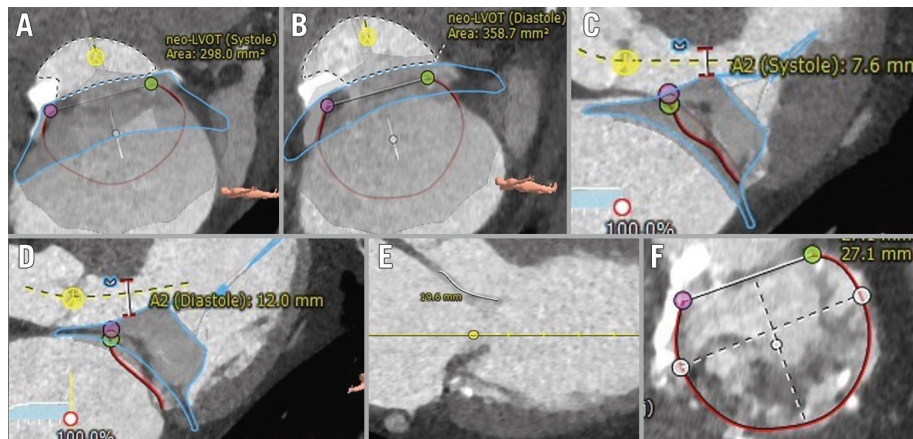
MDCT-derived assessment. Calculation of the neo-LVOT and the distance between the stent frame and the interventricular septum (A2 clearance) in end-systole (A,C), and end-diastole (B,D), respectively. Further, the anterior length on an LVOT view (E), as well as the degree of mitral annular calcification on an en-face view (F), were determined. Adapted and changed from Andreas *et al*¹⁶. LVOT: left ventricular outflow tract; MDCT: multislice detector computed tomography
